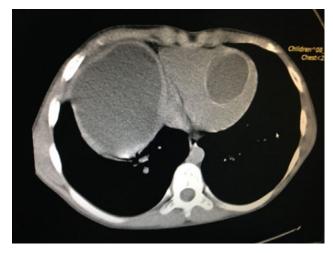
Presence of cyst echinococcus in torachal MRI.
